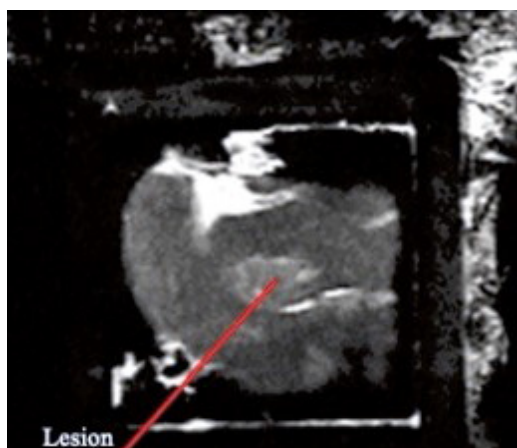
T2-W FRFSE MR image (coronal plane) acquired after *in vivo* sonication at acoustical power of 27 W for sonication time of 40 s with movement of the robotic device in a 3 x 3 grid with a 3 mm step size at 2 cm focal depth.
